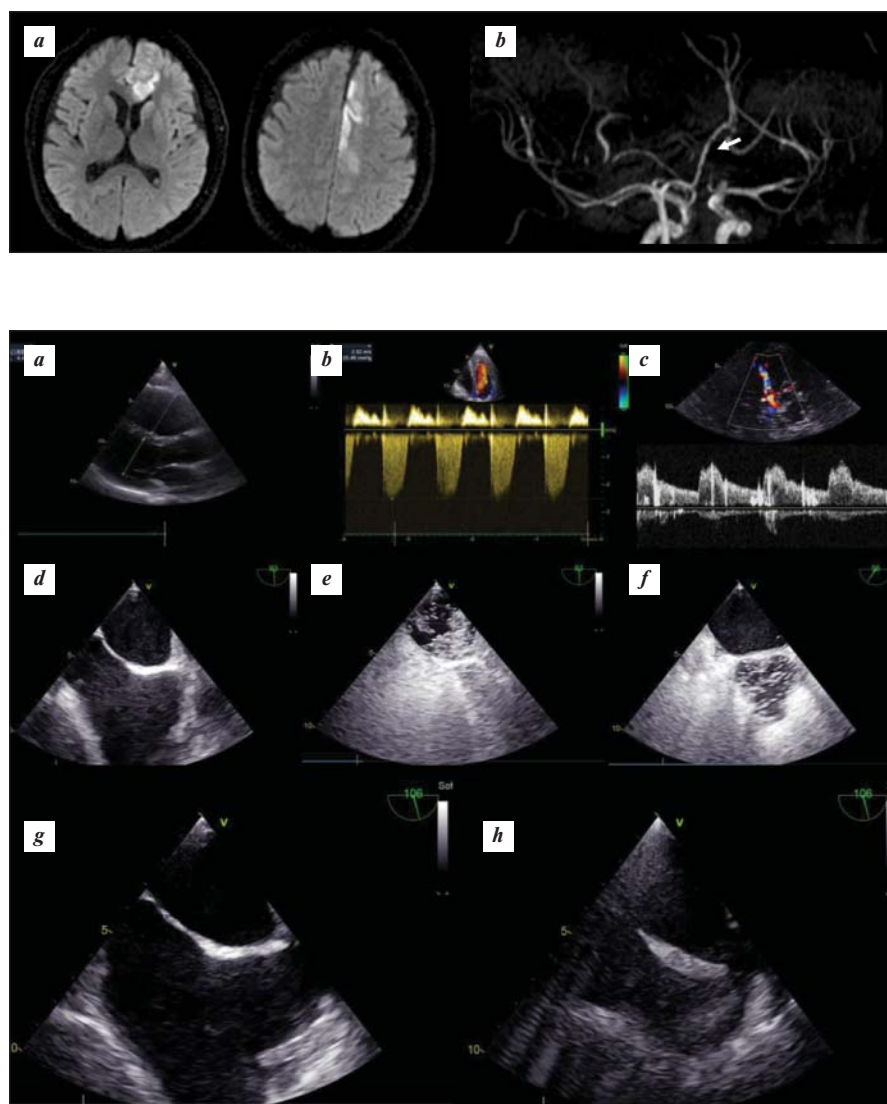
Images obtained with ultrasound methods for examining the patient's M heart. a – transthoracic echocardiogram (TTE), parasternal long-axis plane: right ventricular dilatation, with a predominance of its size over the left; b – TTE, CW, tricuspid regurgitation with signs of increased systolic pressure in the pulmonary artery; c – transcranial duplex ultrasonography, control PW volume is set in the middle cerebral artery. Against the background of a normal signal, hyperechoic signals from microbubbles (HITS) are seen; d – transesophageal echocardiography (TEE), standard bicaval position, the atrial septum looks intact; e – TEE with contrast, standard bicaval position. During the Valsalva maneuver a massive discharge of microbubbles into the left atrium is seen, the source is not visualized; f – TEE with contrast, middle third of the esophagus, short axis views in the vicinity of the aortic valve. After agitated saline injection in the right chambers, a large number of microbubbles appear in the left chambers (already fixed in the aorta), the interatrial septum looks intact; g – follow-up TEE after CT-verification of sinus venosus. Standard bicaval position does not allow visualization of the defect; h – TEE, modified bicaval position, a sinus venosus atrial septal defect is visualized on the right side of the screen
